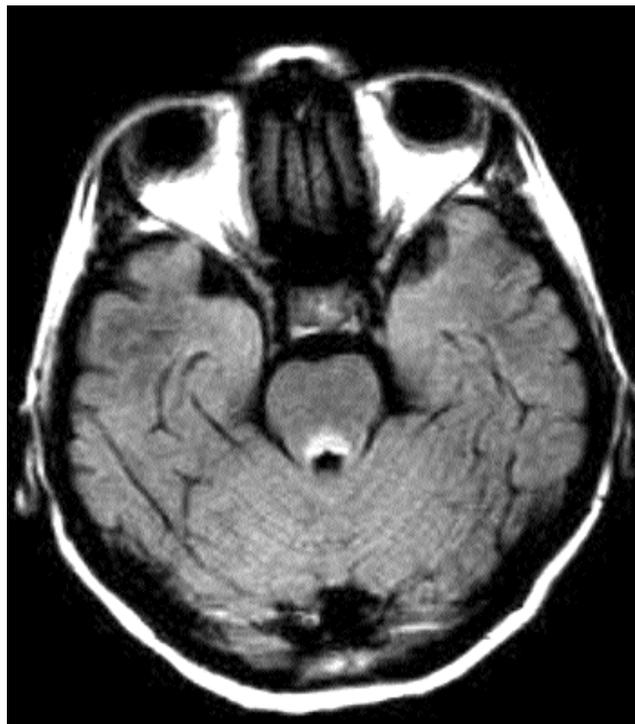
Wernicke's encephalopathy, FLAIR (Fluid-attenuated inversion recovery) axial scan: hyperintensity at the dorsal aspect of the brainstem, anterior to fourth ventricle.
